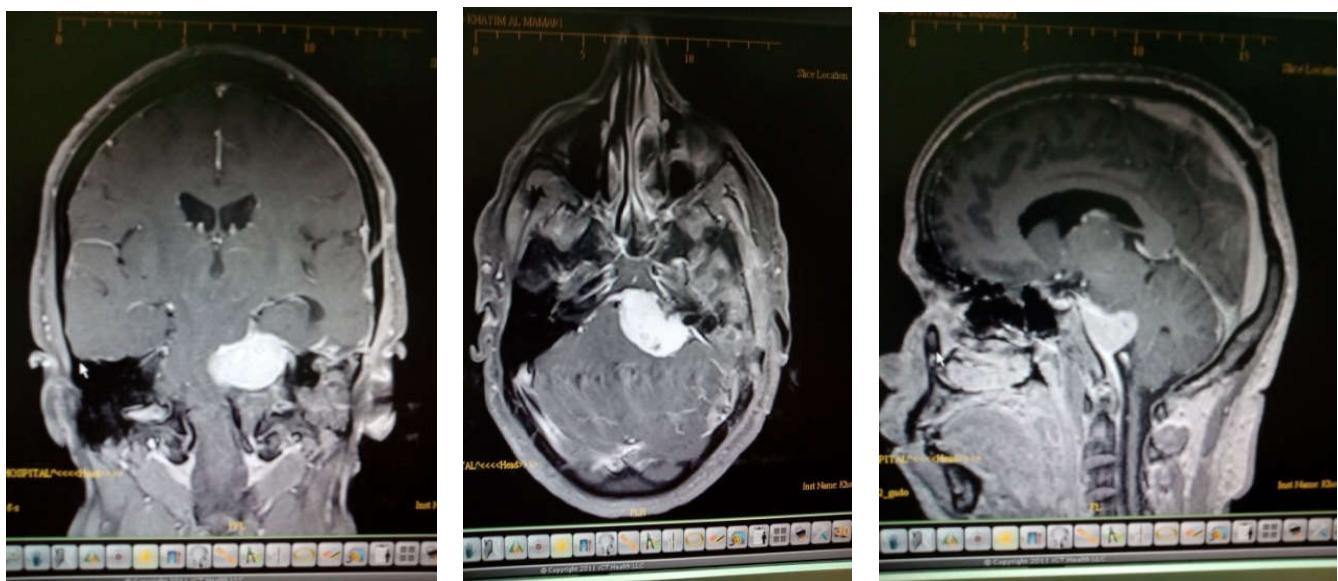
MRI after 1 st stage resection of supratentorial part
